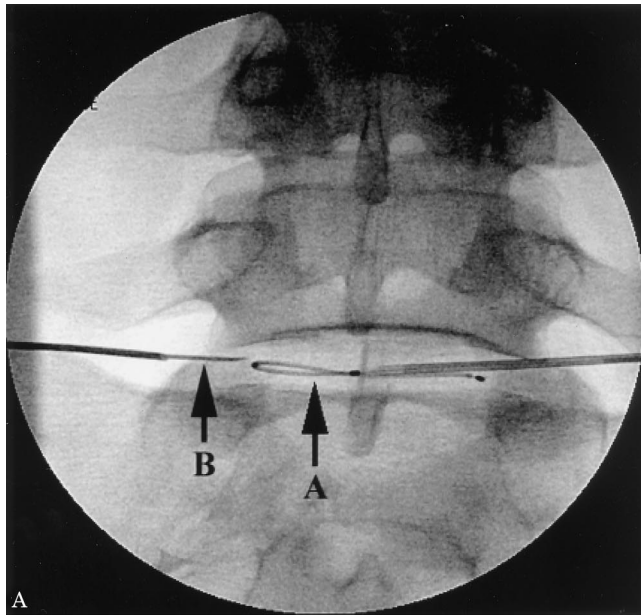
A, Radiograph of catheter (A, arrow) and temperature probe (B, arrow) in place. B, Disc area heated (A, arrow) and temperature probe (B, arrow) placement (epidural space).
